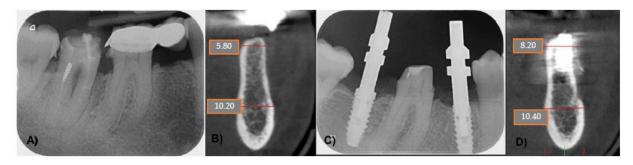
(A) Preoperative intraoral periapical radiograph (IOPA); (B) Initial CBCT; (C) Intraoperative IOPA; (D) CBCT after 4 months.
